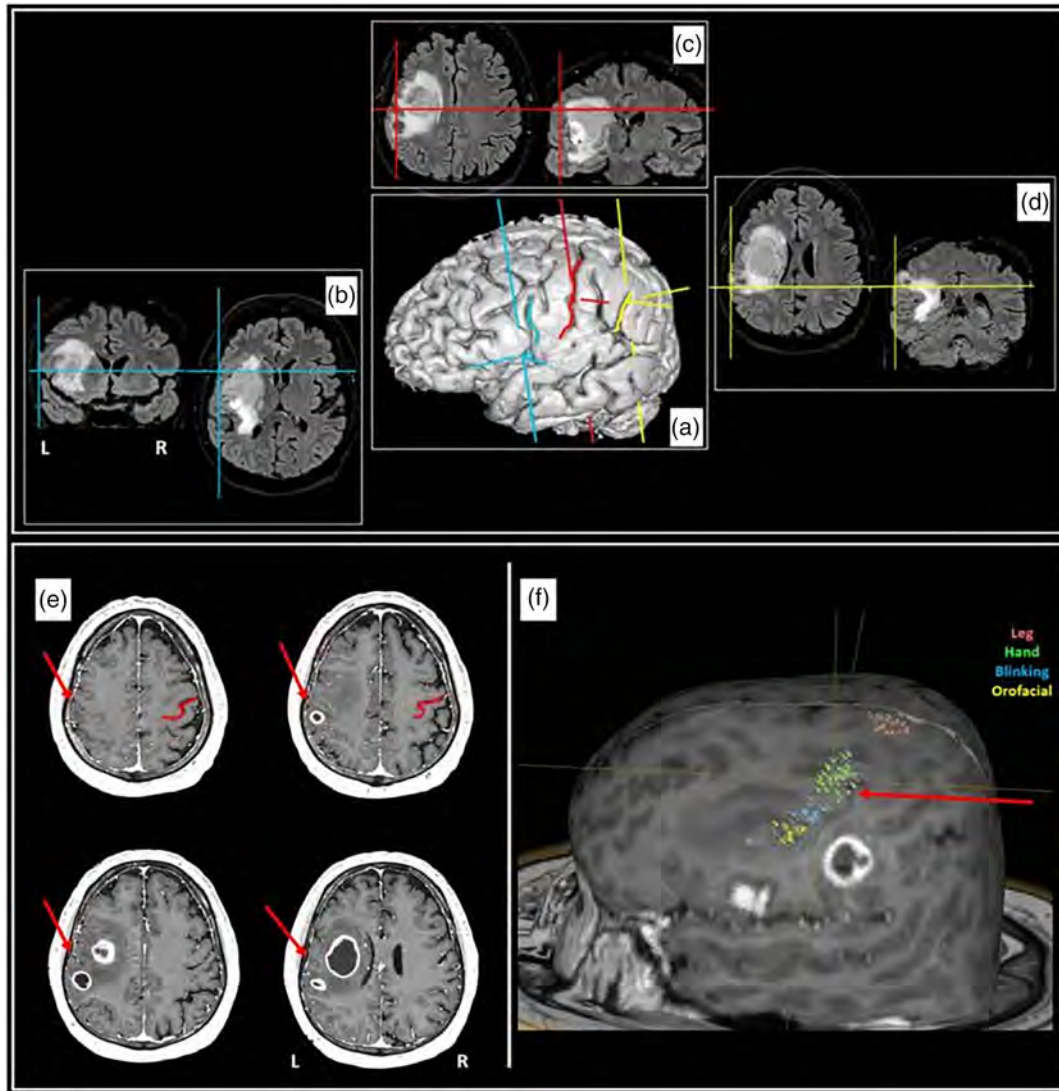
Upper panel. The anterior and posterior limits of the lesions. (a) Surface reconstruction of the brain of the patient: The blue line indicates the anterior border of the lesions, the red line the central sulcus, and the yellow line the ascending posterior lateral fissure, that is, the posterior limit of the lesions. (b) Axial and coronal views of the anterior limit of the lesion, which is located at the level of the precentral sulcus (blue lines). (c) Axial and coronal section at the level of the central sulcus (red lines). (d) Axial and coronal sections of the posterior border of the lesions at the level of the ascending posterior lateral fissure (yellow lines). Each coloured cross indicates, respectively, the same anatomical position. Note that, on the cortical surface reconstruction, it is not possible to localize the tumour that extends from the inferior precentral sulcus (blue lines) as far as the ascending posterior ramus of the lateral fissure (yellow lines). Lower Panel. (e) nTMS map of the motor cortex on the precentral gyrus; axial view of the patient's MRI to show the hand knob (red outline) on the contralateral unaffected hemisphere. (f) The 3D rendering using the Nexstim NBS system of the patient MRI: The coloured dots represent the positive points of the induced motor evoked potentials (MEPs). Brown indicates the leg region, green the hand region, blue the blinking region, and yellow the orofacial region
